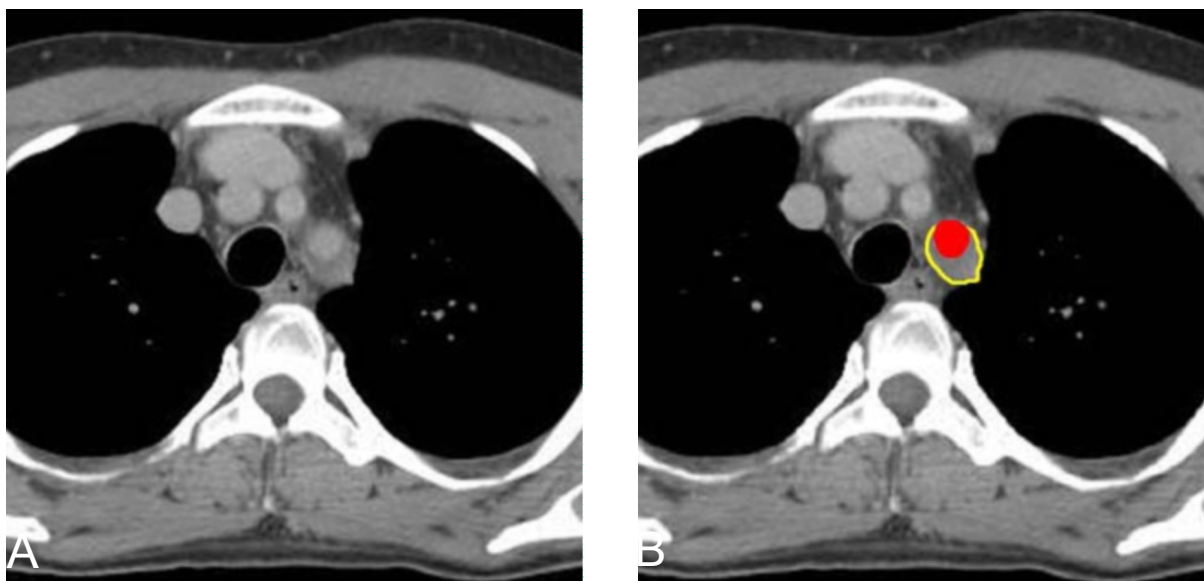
Axial CT with contrast, demonstrating narrowing of the left subclavian artery (without color in 6A, filled in red in 6B) with a surrounding crescent of soft tissue density (without color in 6A, outlined in yellow in 6B).
